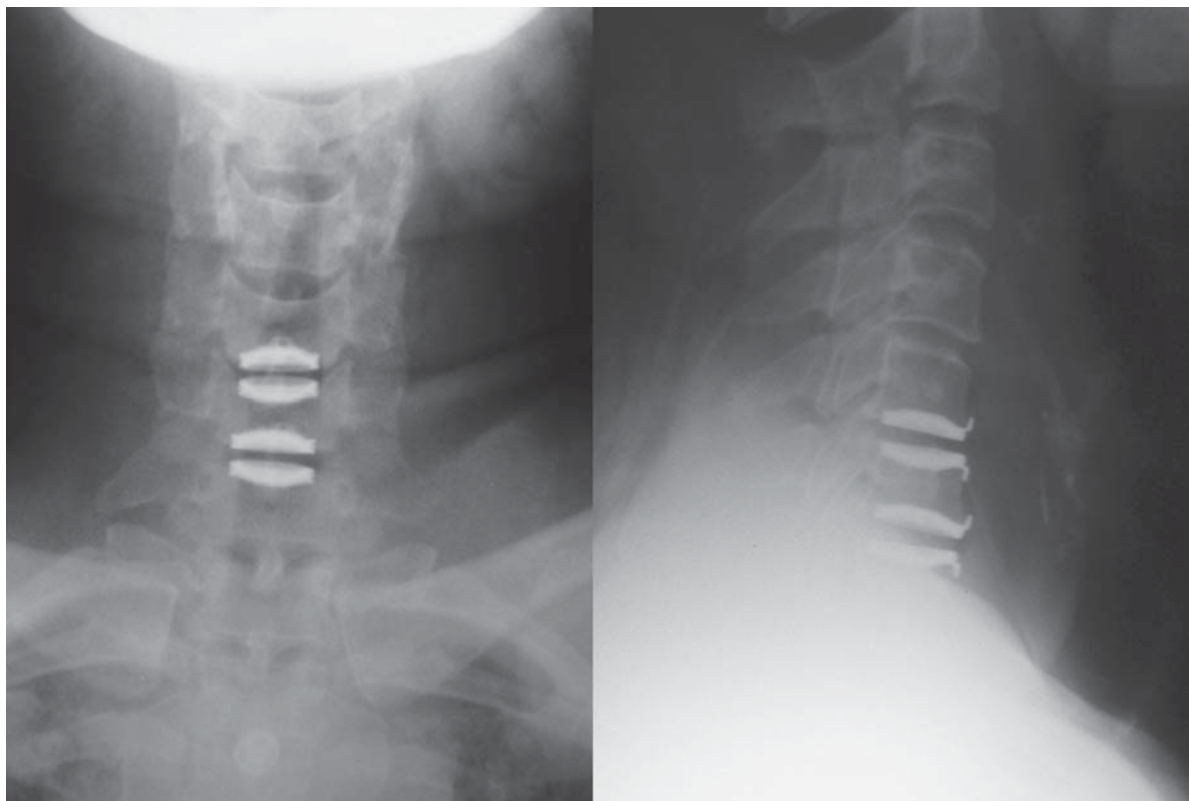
X-rays showing double level Bryan disc prosthesis at C5-6 and C6-7 level.
